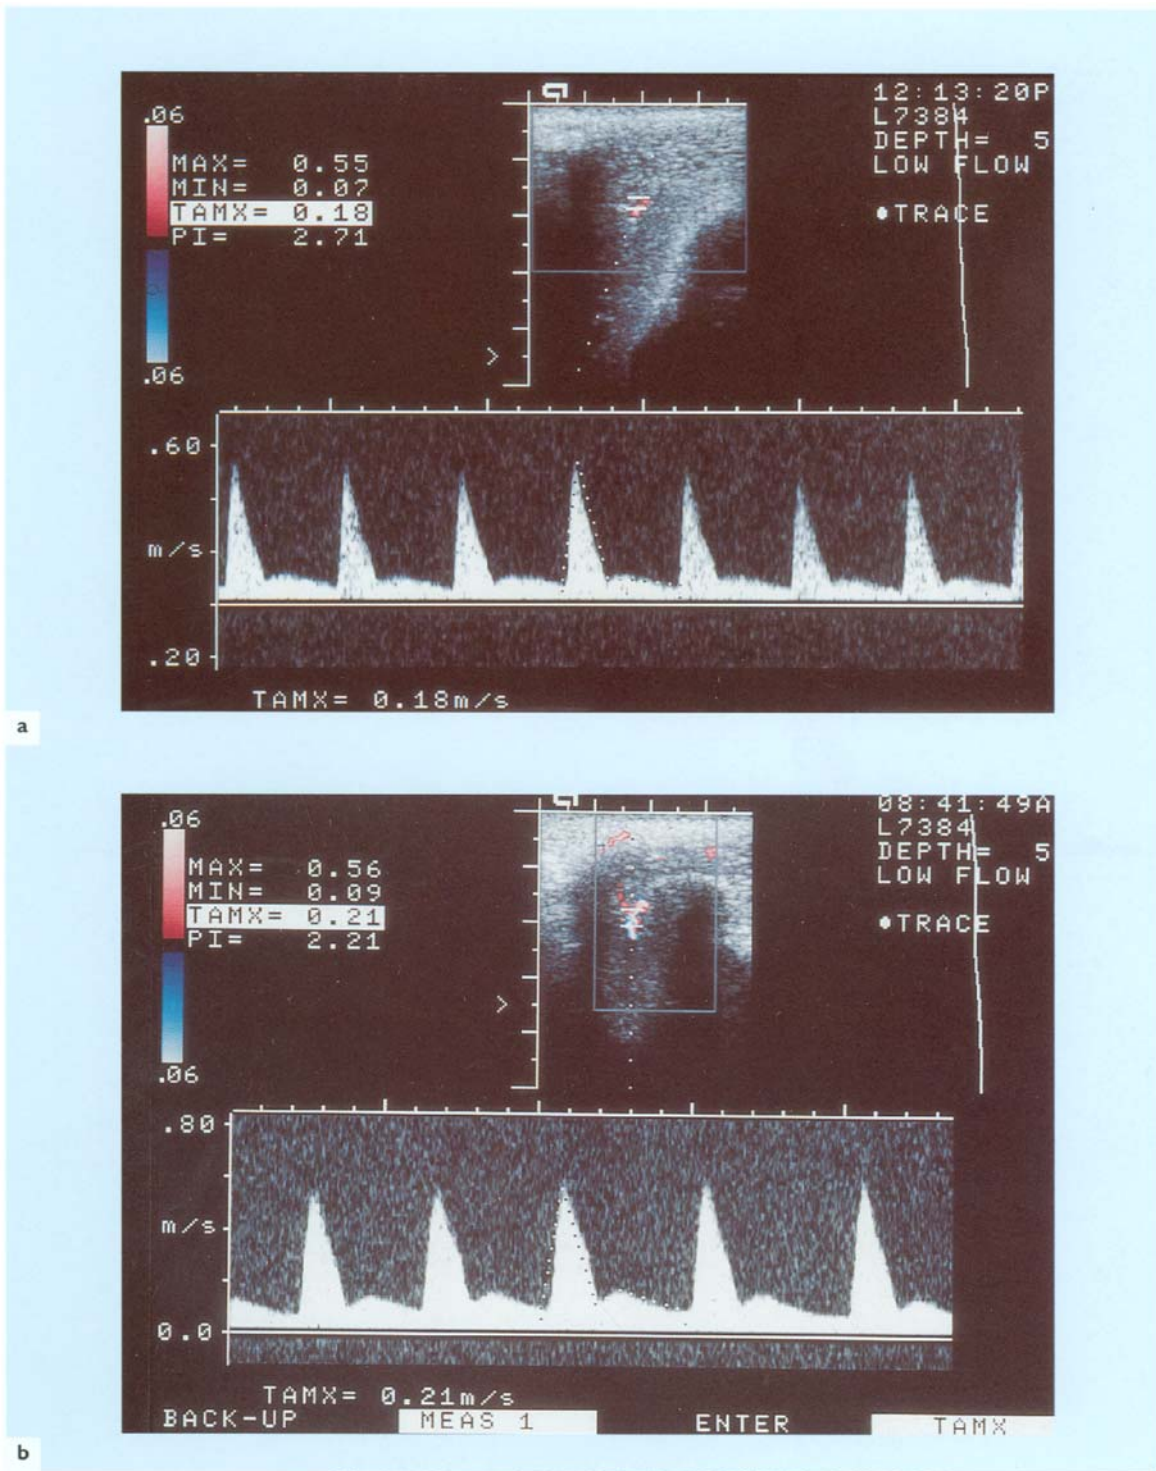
Color duplex Doppler ultrasonography (CDDU) of a patient with (a) arteriogenic erectile dysfunction shows poor tumescence, a normal peak systolic velocity and continuing flow during diastole; CDDU of a patient with venous leak-induced erectile dysfunction (b) shows failure of normal veno-occlusive mechanisms resulting in continuous flow during diastole despite adequate peak systolic velocities
